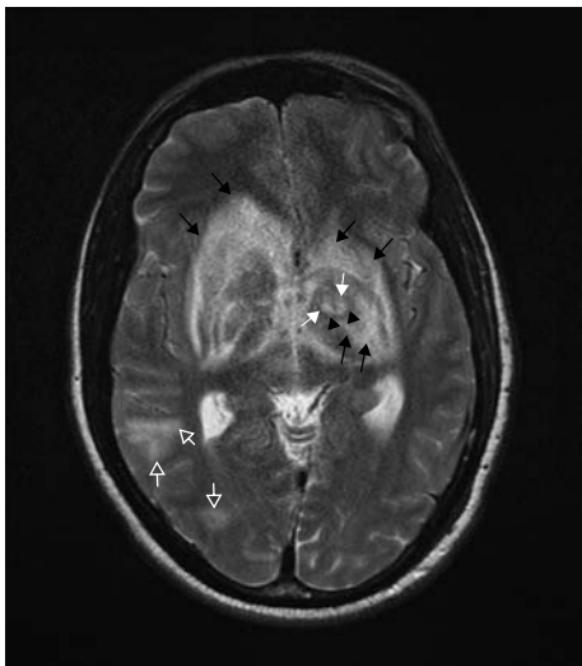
Cerebral toxoplasmosis (axial FLAIR MRI). Bilateral mass lesions with heterogeneous signal intensity in the deep grey nuclei. Target appearance is shown in the left anterior thalamus with a ring of hypointensity (black arrowheads) surrounding an area of hyperintensity (white arrows) and central hypointensity. Note also further lesions peripherally at the grey–white matter junction in the right temporo-occipital region (open white arrows).
